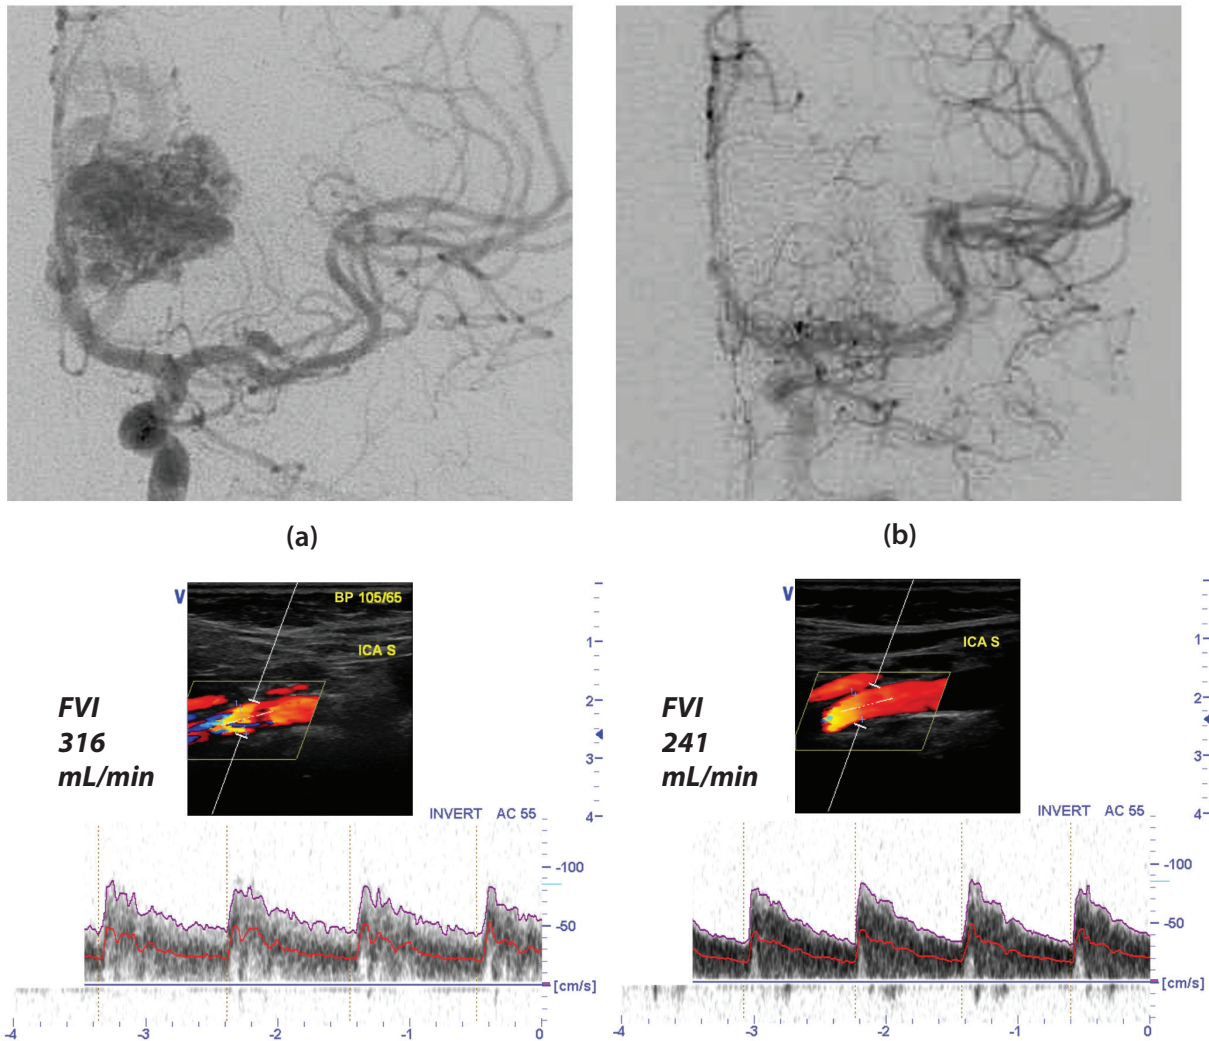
Carotid angiograms and results of color Doppler in the left internal carotid arteries (ICA) with calculation of flow index before (a) and after (b) total arteriovenous malformations (AVM) embolization by Onyx in a 44 year old patient (case 2) with AVM in the left frontal lobe.
